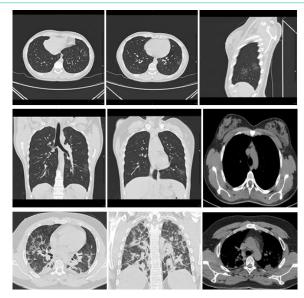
CT scan shows two rounded lobular ground glass opacity (GGO) affecting less than 5% of the entire left lower lobe. A thymic gland is seen in the anterior mediastinum.
